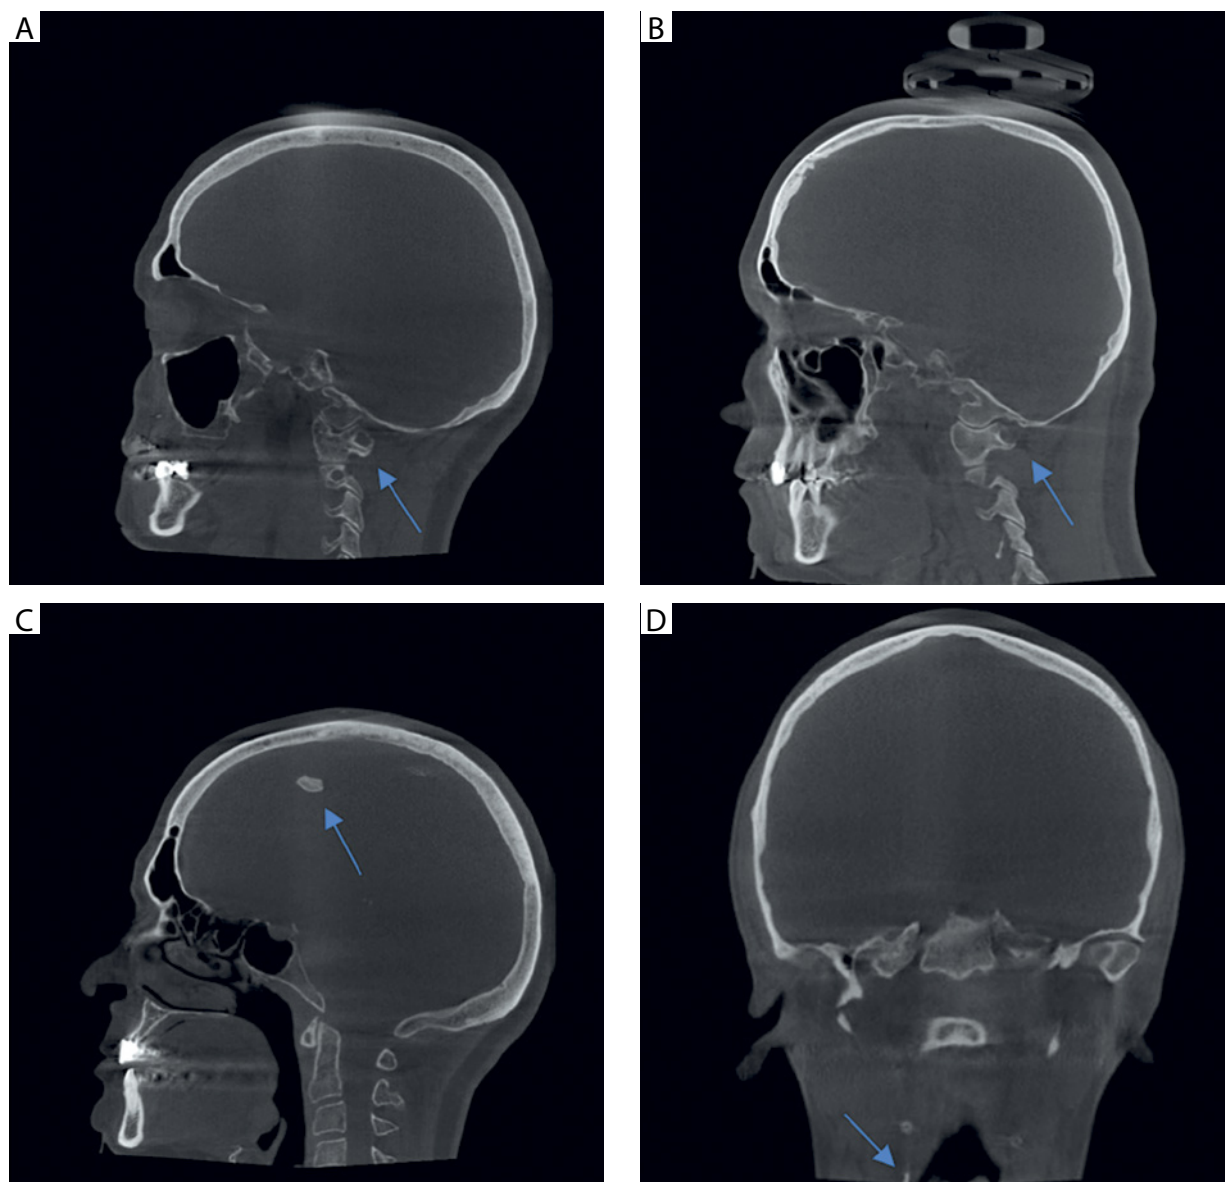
A) Cone-beam computed tomography (CBCT) image of right complete ponticulus posticus. B) CBCT image of right partial ponticulus posticus. C) CBCT image of intra-cranial calcification. D) CBCT of right carotid artery calcification
